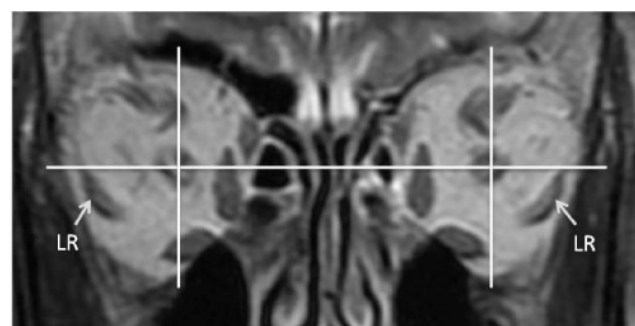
Pre surgical high-resolution orbital coronal sections MRI.
